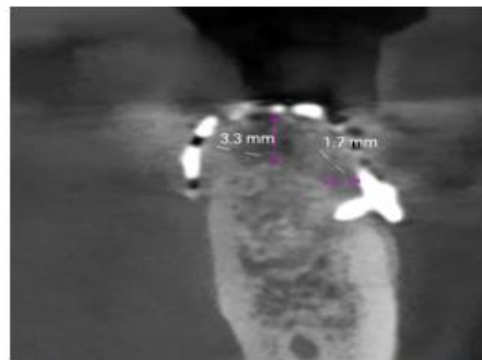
post-operative CBCT showing increase in height
